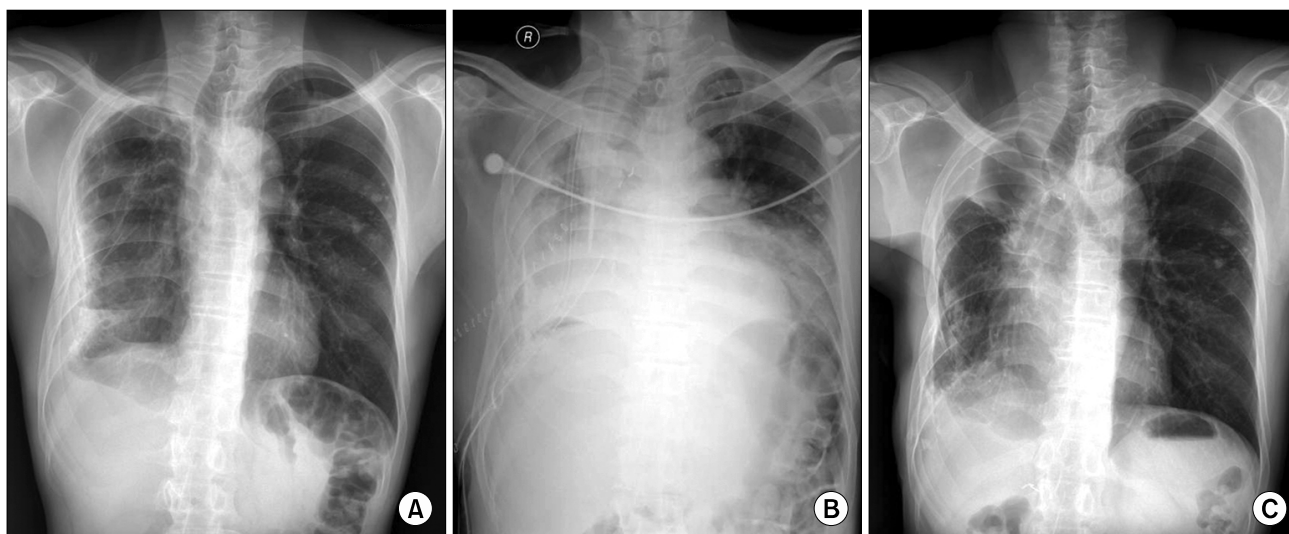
Chest radiograph before operation showed empyema in the right pleural cavity (A), Postoperative chest radiograph (B), and recent chest radiograph (C).
